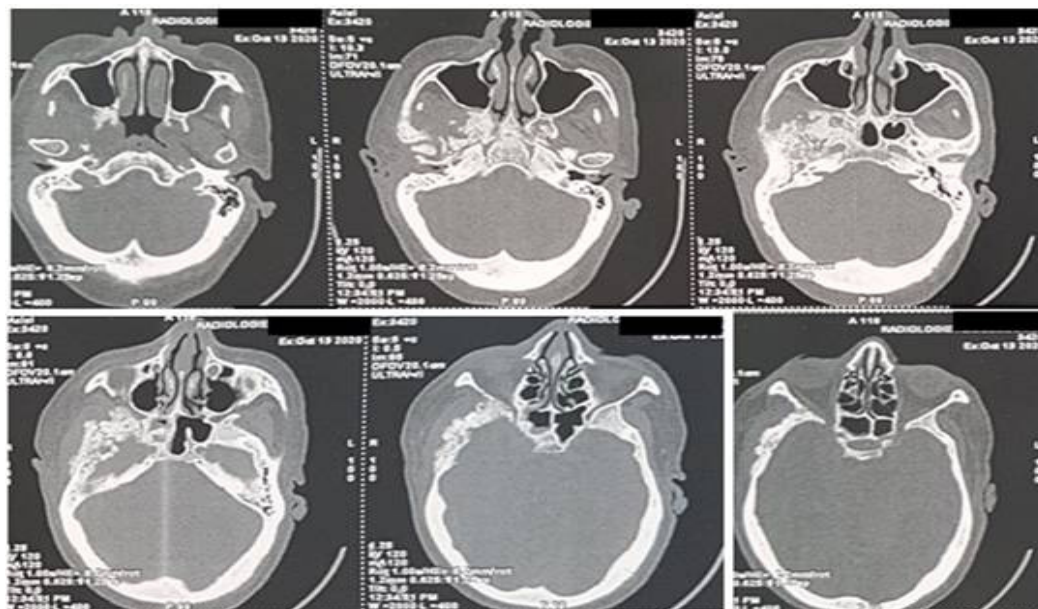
Face CT scan, axial sections: Extension of the osteomyelitis to the lateral orbital wall, the zygomatic arch and the greater sphenoid wing.
